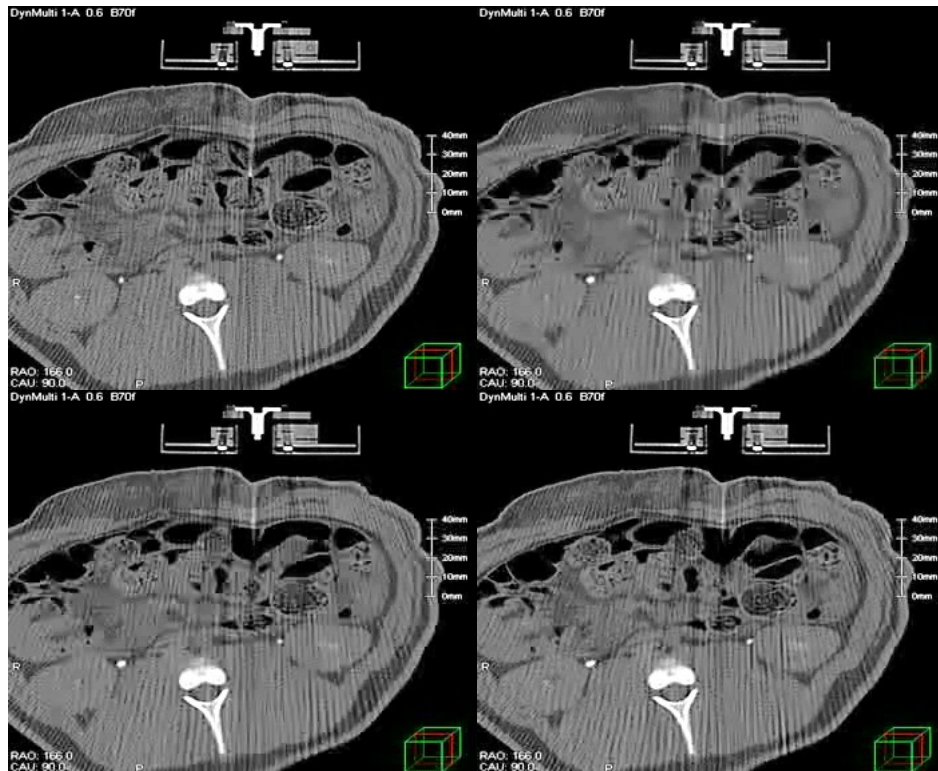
The sequential transversal CT images tracking the needle in No. 1 insertion path
